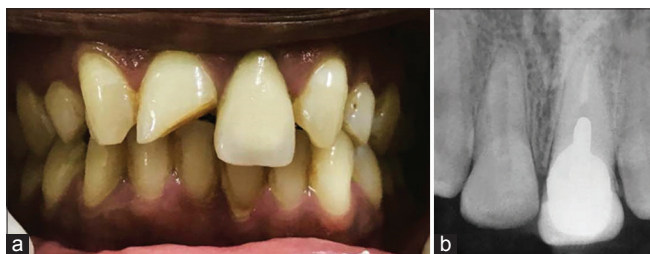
(a) Pre-operative clinical photograph and (b) pre-operative radiograph
